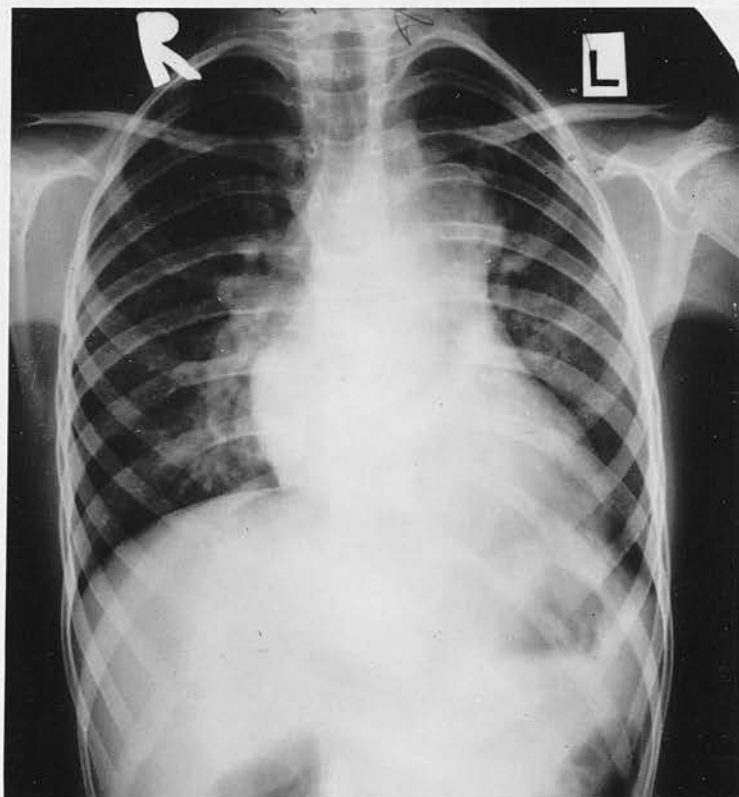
Radiograph of Case 39. Infected Patent Ductus with development of Pulmonary Aneurysm.
